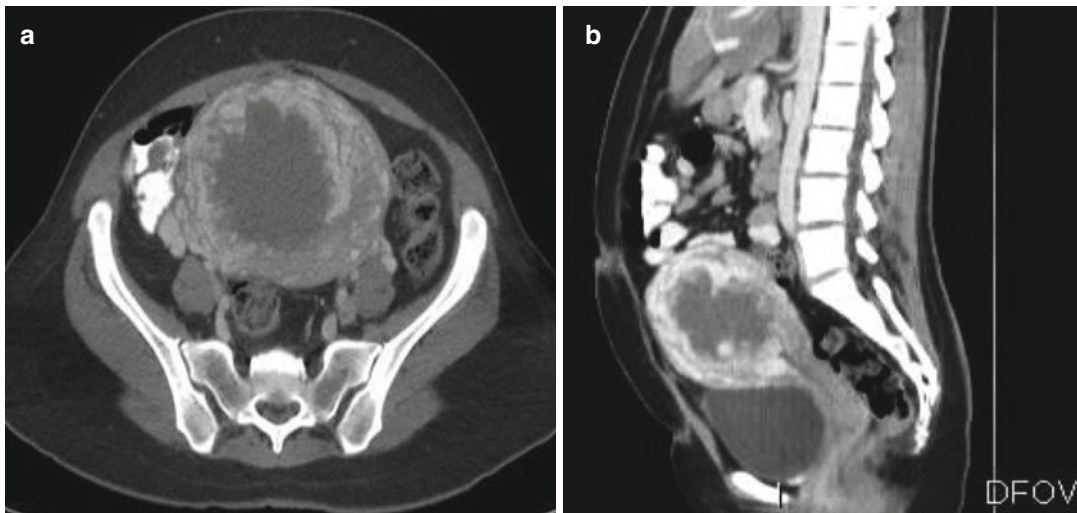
(a, b) Contrast-enhanced axial and sagittal contrast-enhanced CT scan showing central hypodense mass with peripheral enhancing areas in an enlarged uterus (proven choriocarcinoma)
